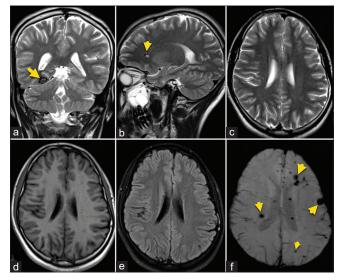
T2-weighted coronal (a) and sagittal (b) images reveal right occipital (arrow) and left frontal (arrow) hyperintense lesions with hypointense margins, consistent with cavernomas. At the level of corona radiata, axial T2-weighted imaging (c), T1-weighted imaging (d), and FLAIR (e) all appear normal, but susceptibility-weighted imaging (f) reveals multiple foci of hypointensities (arrows in f), suggesting cavernomas, which are not visible on conventional T1-weighted, T2-weighted, and Fluid attenuated inversion recovery (FLAIR) images
